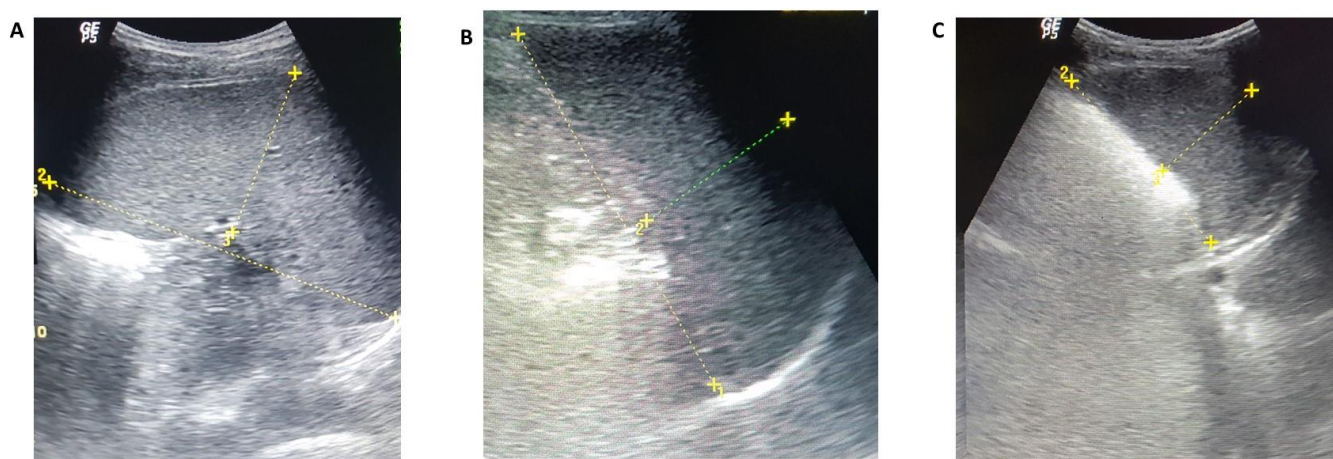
Abdominal ultrasonography showing enlarged spleens among SCD patients
